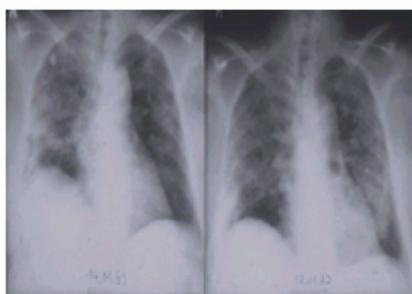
Radiographic manifestation of alveolar haemorrhage in Wegener's granulomatosis.
